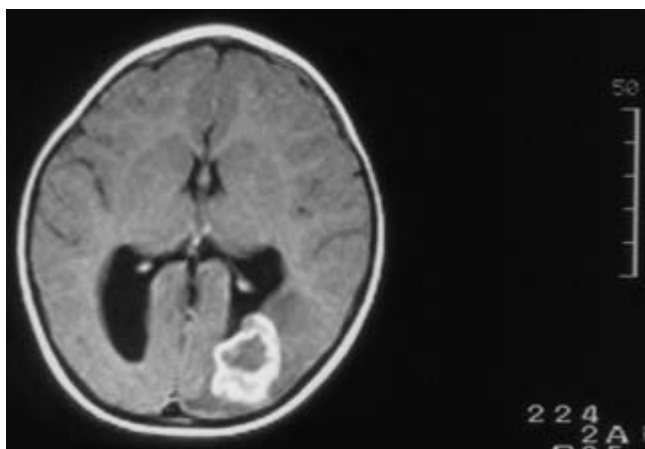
Patient no. 10. Axial T1-weighted image after contrast medium administration. Pathological, contrast-enhancing mass in the left occipital lobe, with edema and mass effect – most likely representing neoplastic lesion. Colpocephaly.
